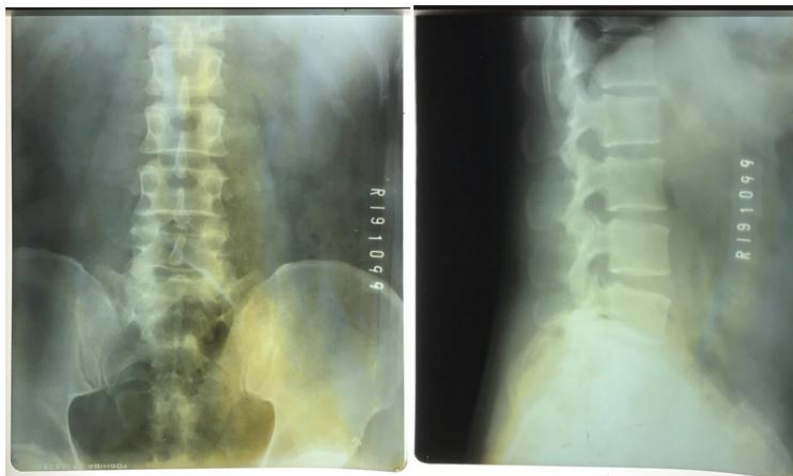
Lumbar Xray AP and Lateral View after Open Discectomy
